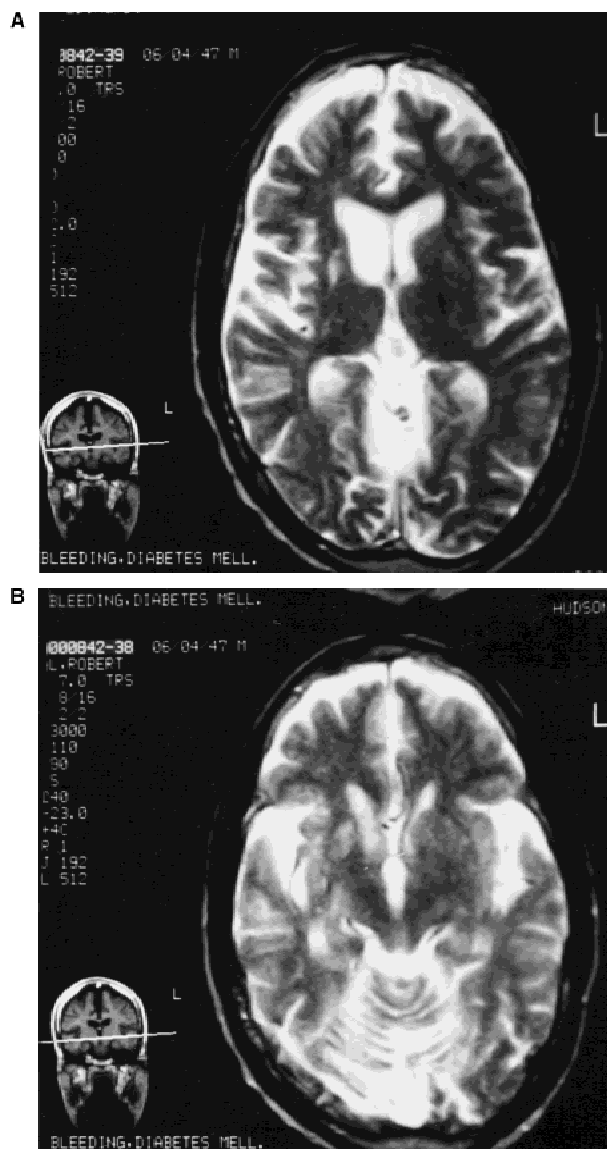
(A and B) T2-weighted MRI demonstrating an infarct in the right caudate and putamen with resulting dilatation of the lateral ventricle. Diffuse cerebellar atrophy is also noted.
